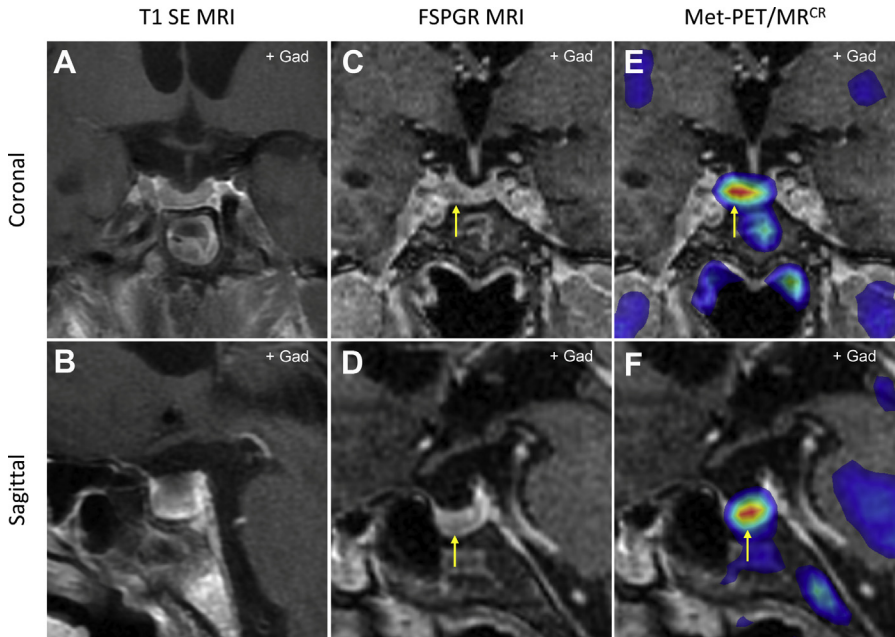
Identification of the site of an occult microadenoma in acromegaly. (A, B) T1 SE MRI demonstrates equivocal findings with no discrete adenoma visualized. (C, D) Volumetric (FSPGR) MRI identifies a 5-mm focal hypointensity in the right inferior aspect of the gland (*arrow*) suggestive of a microadenoma. (E, F) Met-PET/MR^{CR} reveals an area of focal high tracer uptake (*arrow*) at the site of the suspected microadenoma.
